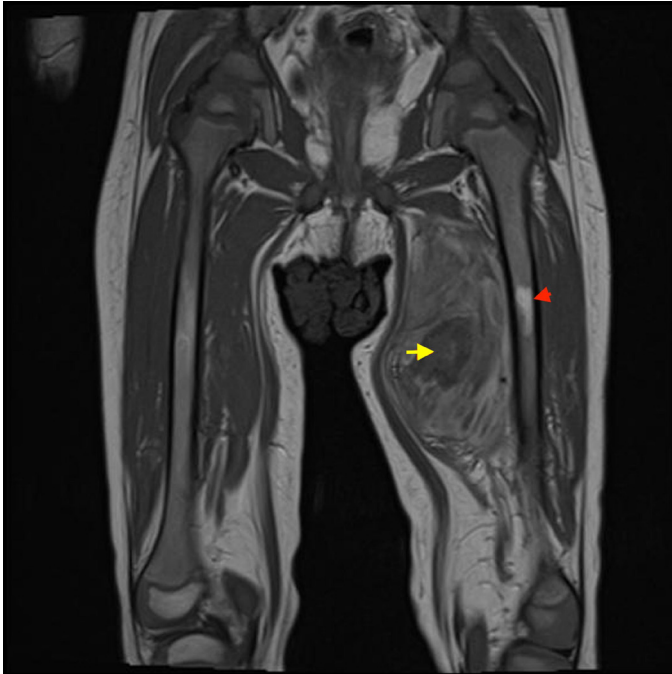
On MRI, the yellow arrow shows the soft tissue mass in the left thigh's medial border, and the red arrow shows the bone involvement of the soft tissue mass
